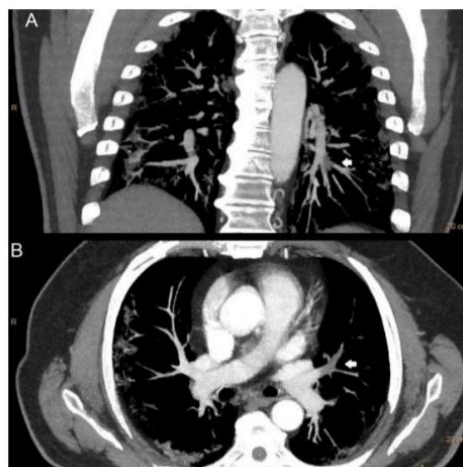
Images in a 65 year old man with COVID-19 pneumonia. A, coronal thick maximum intensity projection slab of CT pulmonary angiography demonstrates a filling defect (white arrow) in a segmental artery for the left lower lobe. B, axial thick maximum intensity projection slab of CT pulmonary angiography shows another filling defect (white arrow) involving lingular artery.
